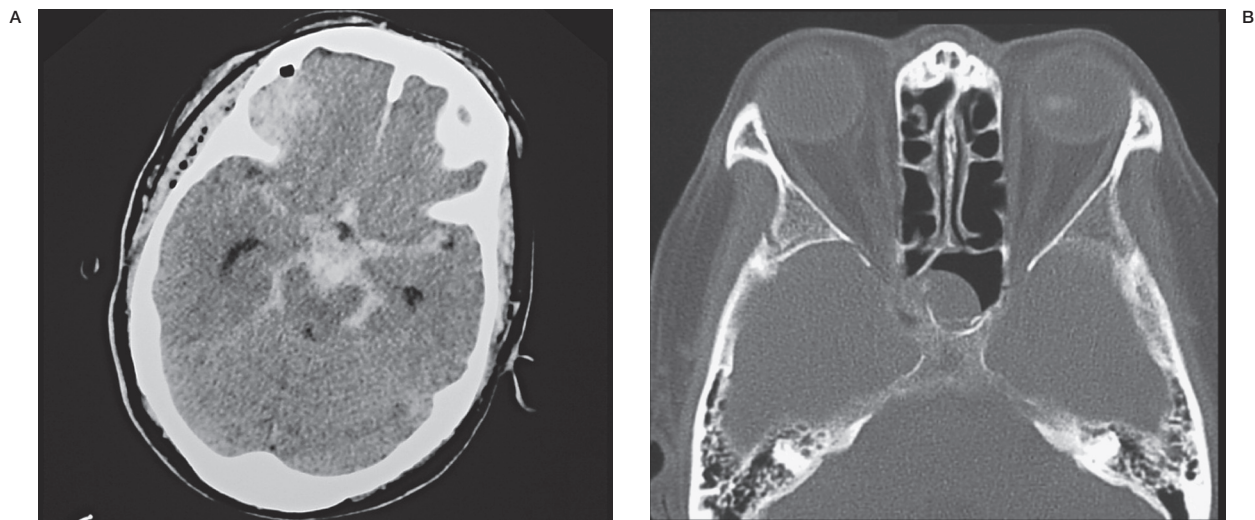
Computed tomography revealed diffuse subarachnoid hemorrhage (A) and bone fracture located in the medial part of the greater wing of the sphenoid (B).
